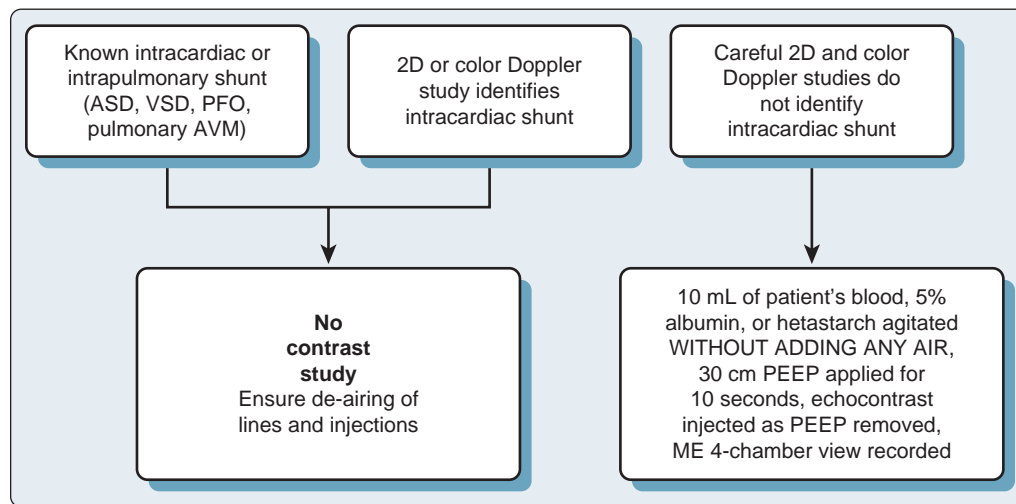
Algorithm for performance of intraoperative echocardiographic contrast study for pulmonary thromboendarterectomy procedures. ASD, Atrial septal defect; AVM, arteriovenous malformation; ME, midesophageal; PEEP, positive end-expiratory pressure; PFO, patent foramen ovale; VSD, ventricular septal defect; 2D, two-dimensional.
